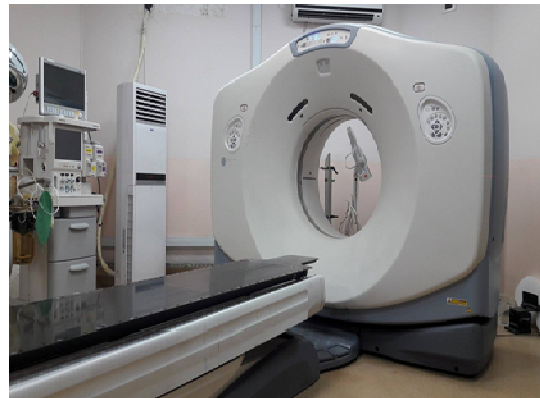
GE Optima 580 CT scanner [8].
